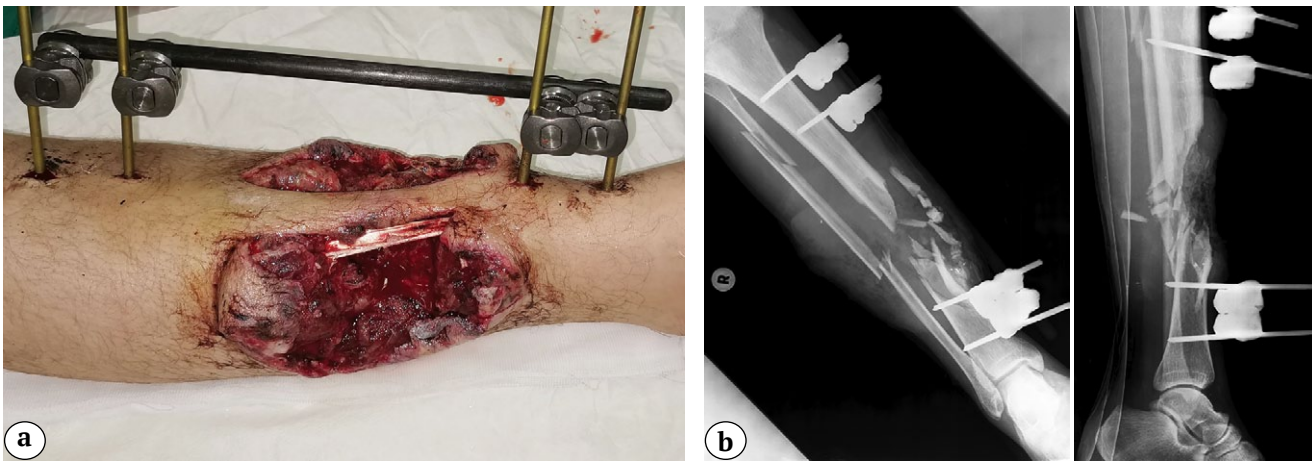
View (a) and X-rays of the patient's right lower leg in frontal and lateral projections (b) upon admission to the clinic: gunshot fractures of the tibia and fibula, fixation with the MFRK device (2 rods in each fragment)
